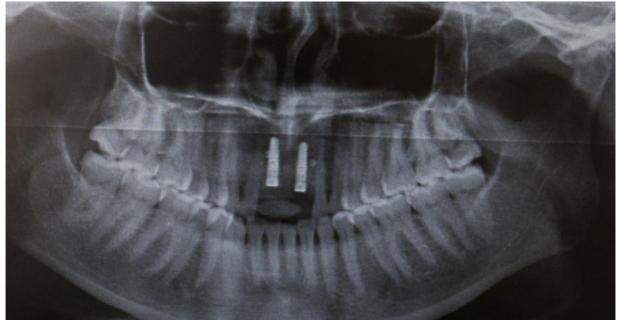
Panoromic radiograph 3 months after
